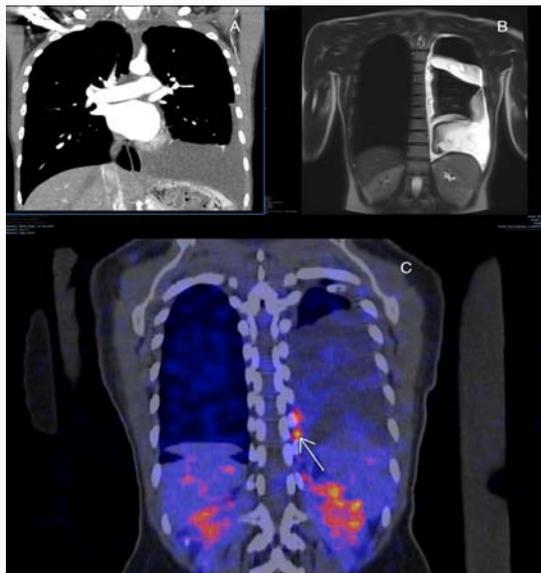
Imaging results: A). Chest CT scan disclosing left pleural effusion; B). MR Lymphangiography; C). Lymphoscintigraphy showing a leak at T10 level (white arrow).
